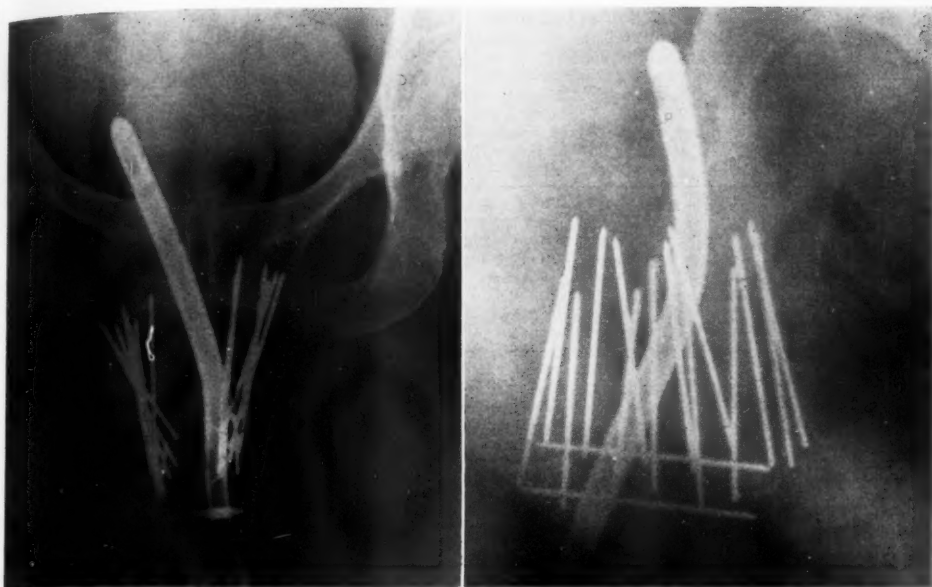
Anteroposterior and lateral radiographs (Case 11537). Separation of planes 3 cm. Average area of planes 27 sq. cm.
